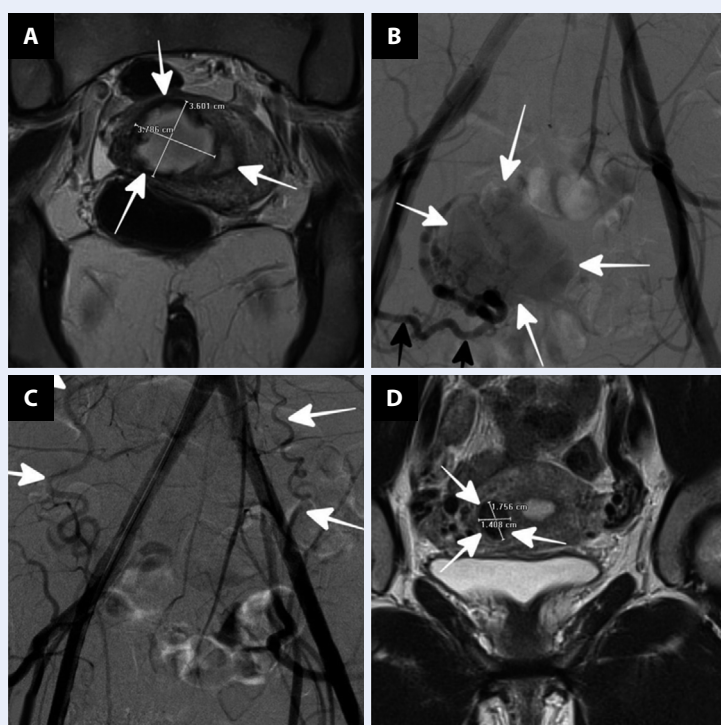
A. Coronal magnetic resonance imaging (MRI) with visible uterine aneurysm (arrows); B. Digital subtraction angiography of the pelvis before embolization. Contrast agent in the iliac and right uterine arteries (black arrows) and uterine aneurysm (white arrow); C. Digital subtraction angiography of the pelvis after embolization. Invisible uterine arteries and aneurysms. Arrows indicate bilaterally dilated ovarian arteries; D. Sagittal MRI of the pelvis 12 months after embolization. Arrows indicate fibrotic uterine aneurysm
